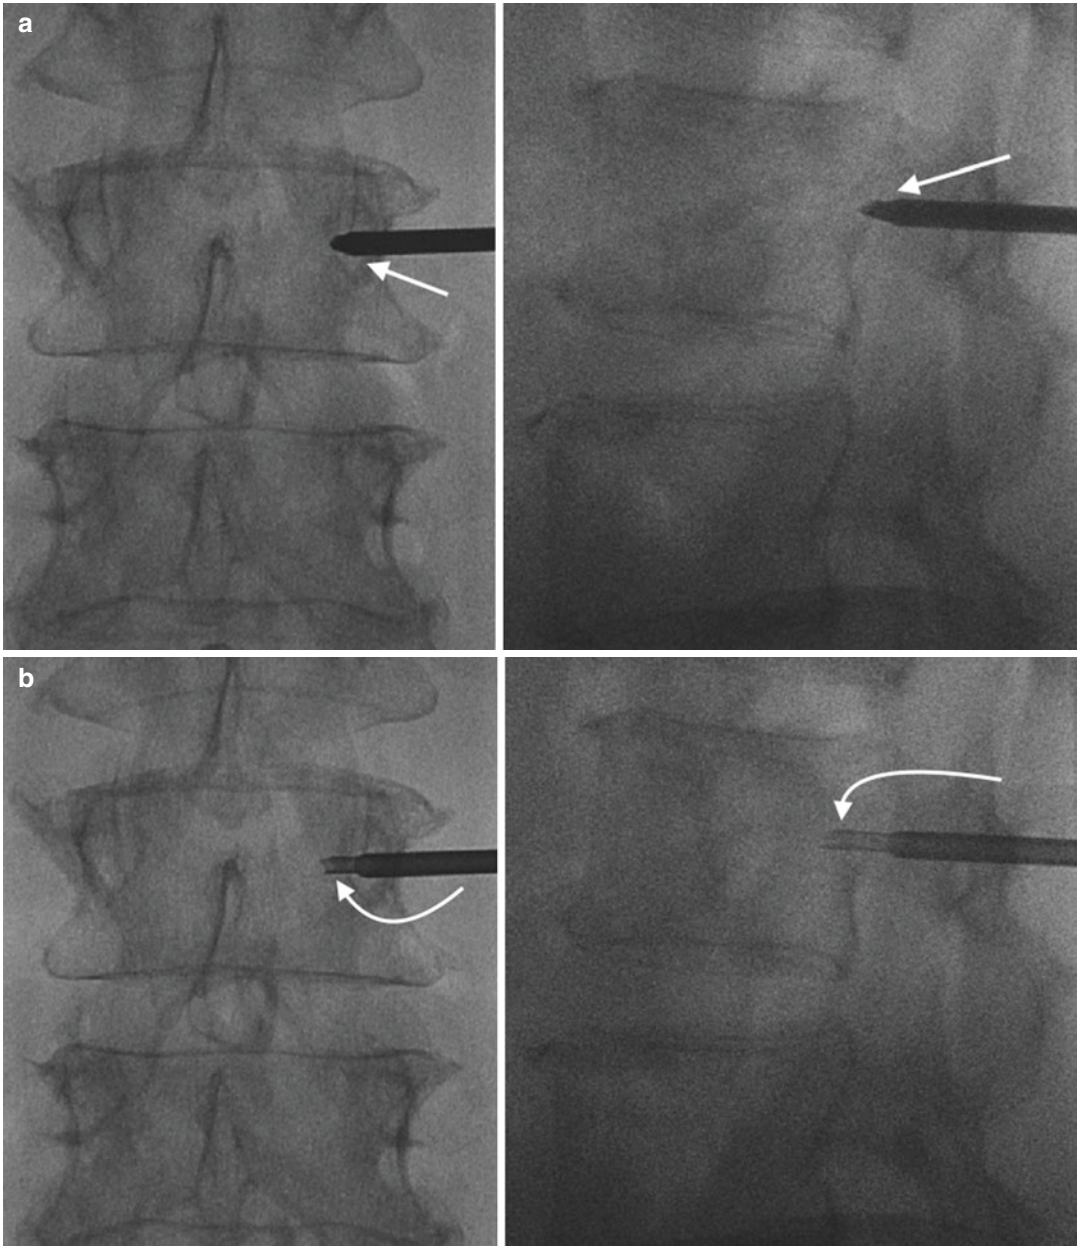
A 63-year-old female with a prior history of breast cancer, low back pain, and an L3 bone lesion detected with an MRI study. Frontal and lateral fluoroscopic images of the lumbar spine (a) show transpedicular bone needle placement with advancement toward the posterior vertebral body (arrows). A bone biopsy is performed (b) at the posterior vertebral body (arrows) with a biopsy cannula using coaxial technique. Continuous sequential fluoroscopic monitoring shows advancement of the bone needle for a second pass (c) within the posterior
